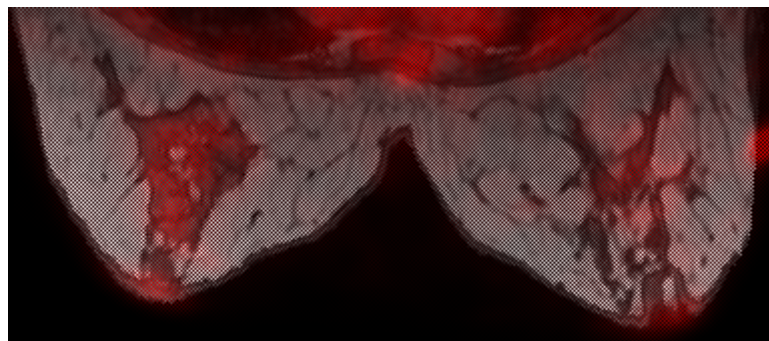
Image created by interlacing PET and MRI data. PET image data is displayed using a red color table and MRI with a grayscale.
